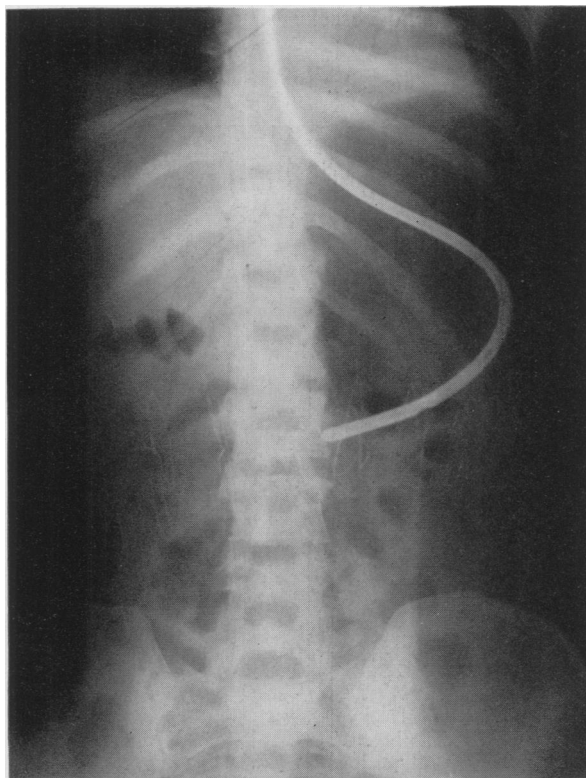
B. B. Unit #784094. Case 5. X-Ray of abdomen taken after operation.
